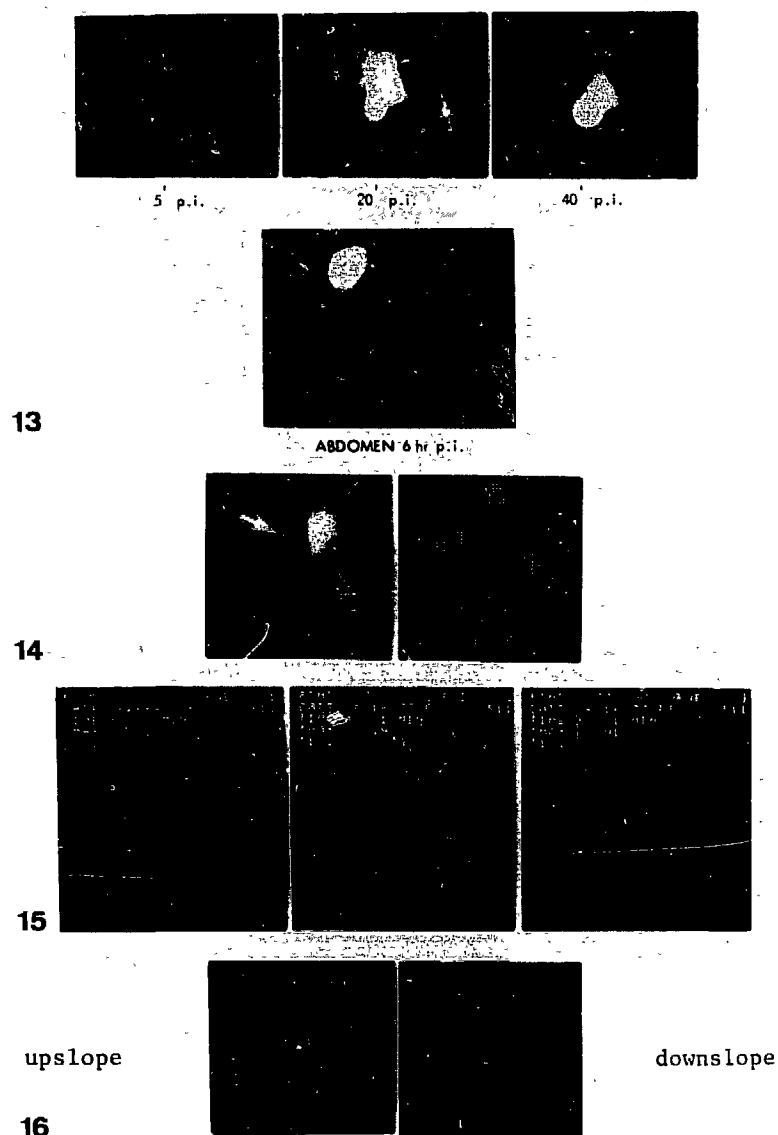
13-16 Cholescintigraphy in a patient with several metastases in right and left liver lobe.
